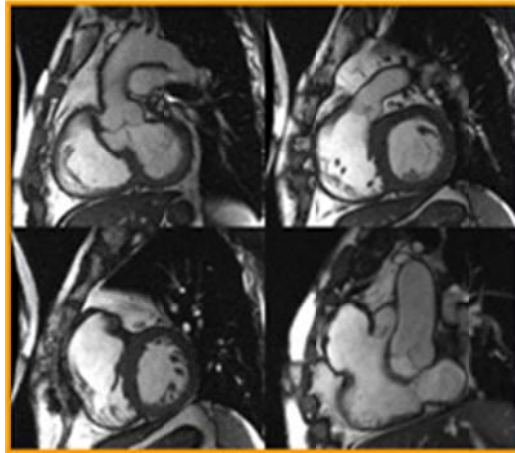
MRI displaying the dilated RVOT of a post-operative tetralogy of Fallot patient, image courtesy of the Children's Hospital of Wisconsin.
